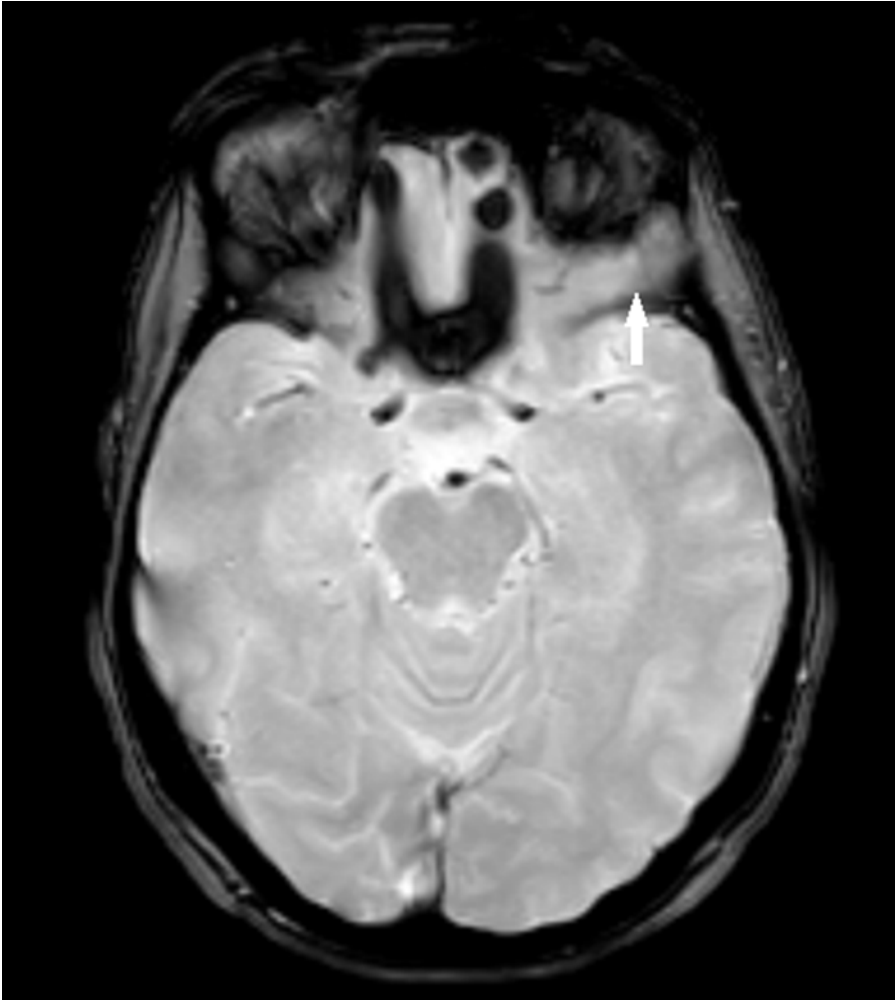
A cerebral CT scan show a hypodense lesion infiltrating the left and sphenoidal localization with a lytic lesion invading the left cavernous groove(arrow) .
